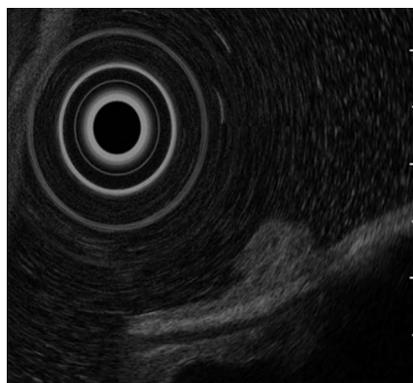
Endoscopic ultrasonography. Endoscopic ultrasonography showed a protruding lesion 8 mm in diameter in the mucosal layer that did not affect the submucosal layer.
